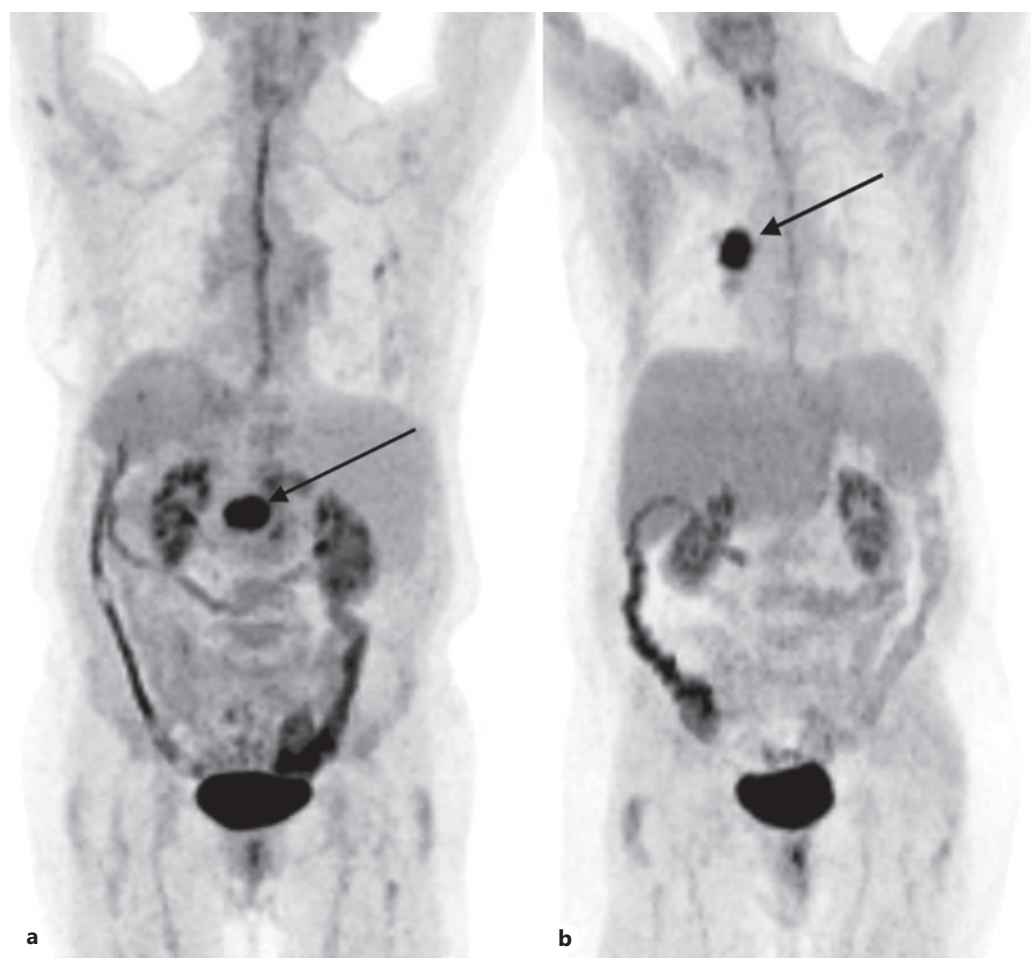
a MIP image showing FDG-avid pancreatic head mass and no lung mass in September 2022. b MIP image showing FDG-avid lung mass and no abdominal masses in April 2020. FDG, fluorodeoxyglucose.
